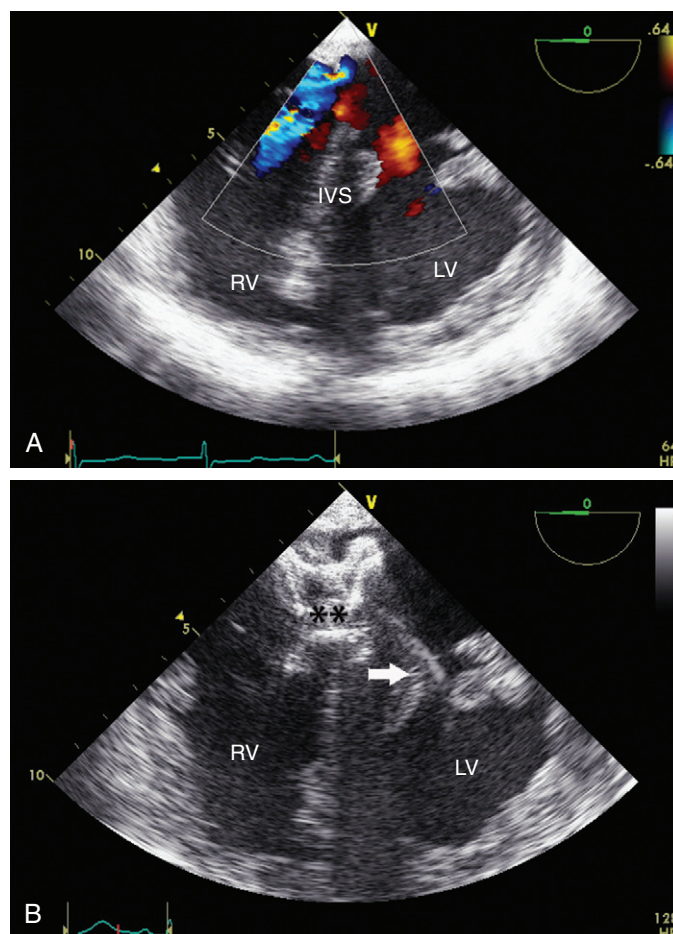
Three days after an acute inferior myocardial infarction, clinical deterioration and a new systolic murmur were observed in this patient. A, Transesophageal transgastric view at 0 degree with color Doppler showed a shunt from the left to the right ventricle, typical of a ventricular septal defect (VSD). B, TEE guidance of percutaneous closure of this VSD. IVS, interventricular septum; LV, left ventricle; RV, right ventricle; arrow, delivering catheter; , Amplatzer device.
